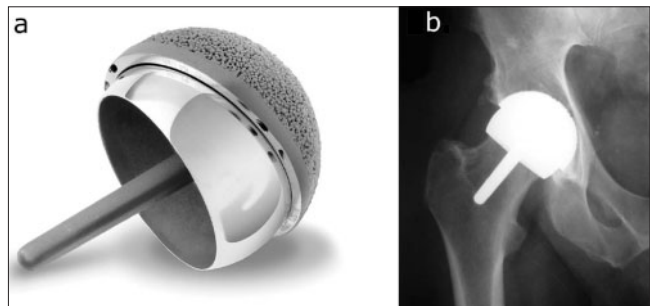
(a) Birmingham Hip Resurfacing components. (b) 7-year follow-up X-rays of a patient aged 45 years at operation.
